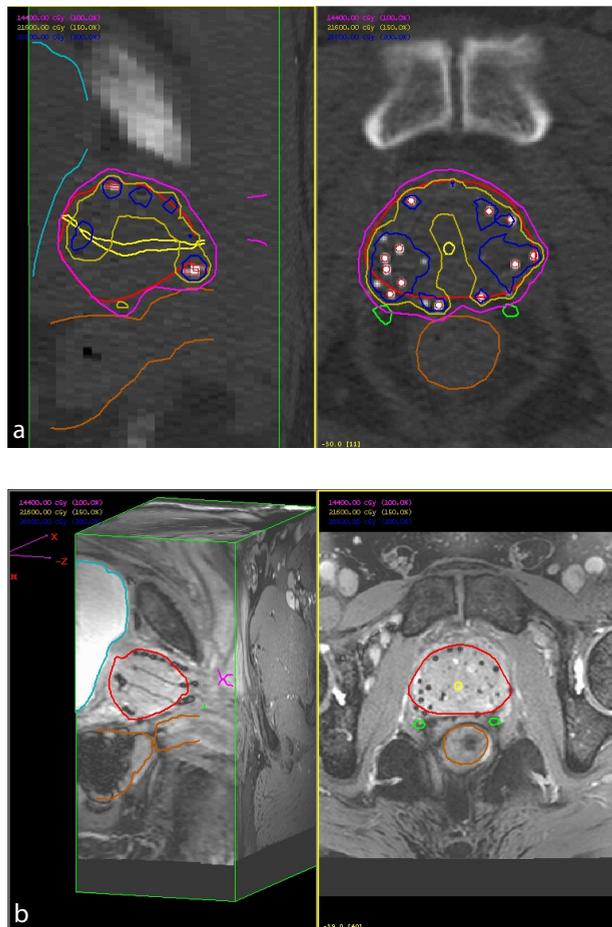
Registration between magnetic resonance imaging (MRI)-based seed localization (a) and computed tomography (CT)-based seed localization (b). Delineation was performed on MRI (a). Dose distribution is shown in Fig. b. Delineation: red = prostate contour; yellow = urethra; brown = rectum; green = neurovascular bundle; and light blue = bladder. Isodose lines (a): pink = 144 Gy (100%); yellow = 216 Gy (150%); and dark blue = 288 Gy (200%).
